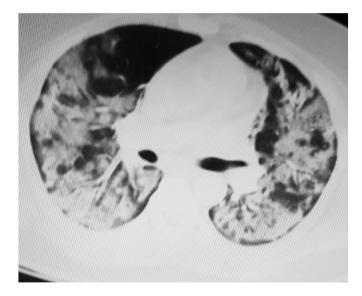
CT axial chest at below the carina demonstrates bilateral consolidations with resolution of pneumomediastinum.
